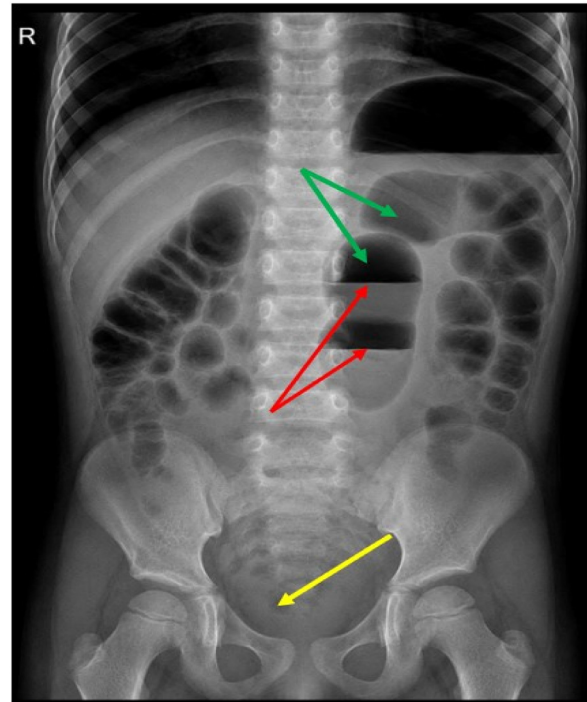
Erect abdominal X-ray demonstrating centrally located dilated small bowel loops (green arrow) with multiple air-fluid levels (red arrow) and relative paucity of gas in the rectum (yellow arrow) and a distended stomach containing an air-fluid level, consistent with complete mechanical small bowel obstruction.
